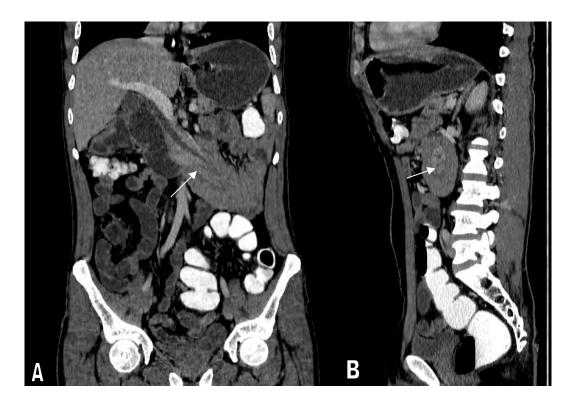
Contrast enhanced CT abdomen in coronal and sagittal reformatted images (A and B) shows sausage shaped mass in left hypochondrium forming a bowel within bowel appearance or donut sign on sagittal reformatted images (arrow)
